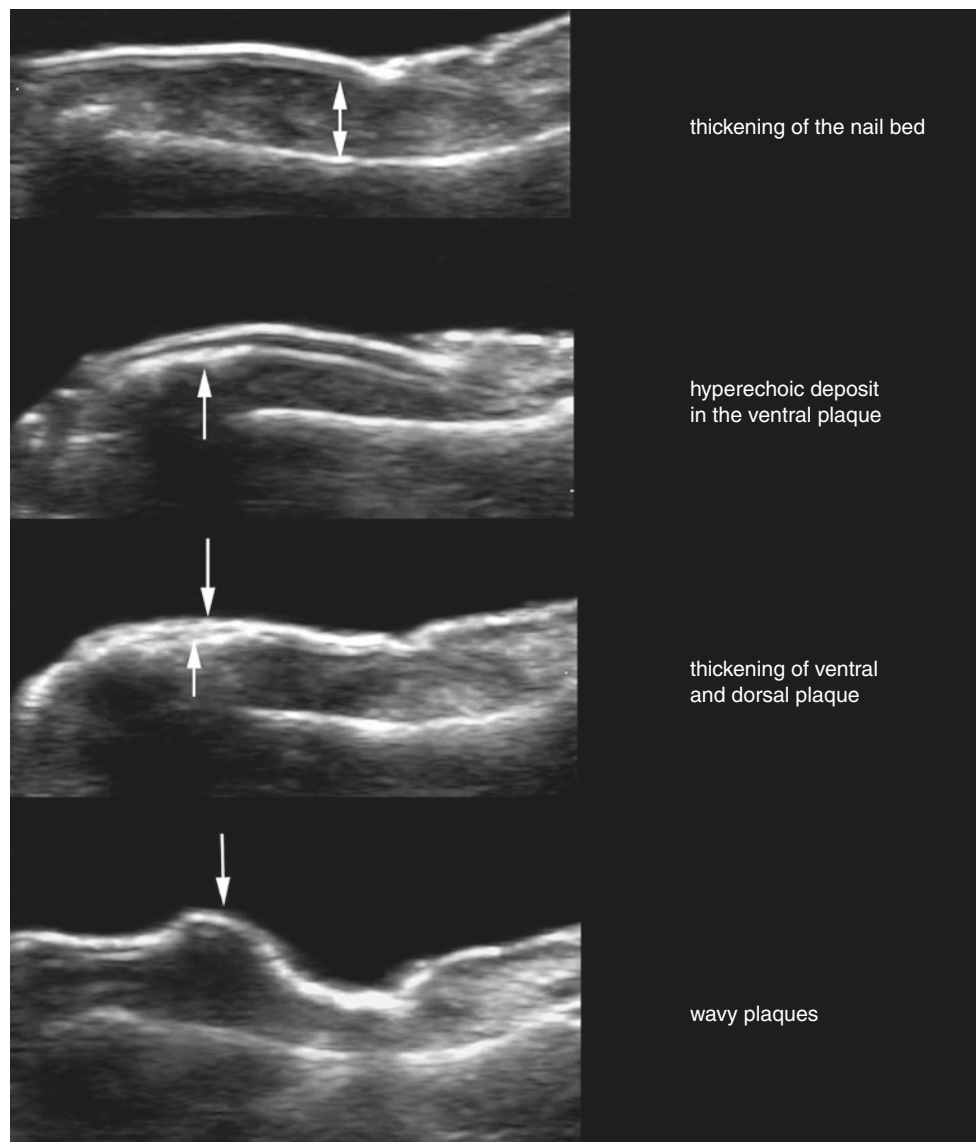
Nail psoriasis. Greyscale (longitudinal views) sonographic signs of psoriatic onychopathy.
